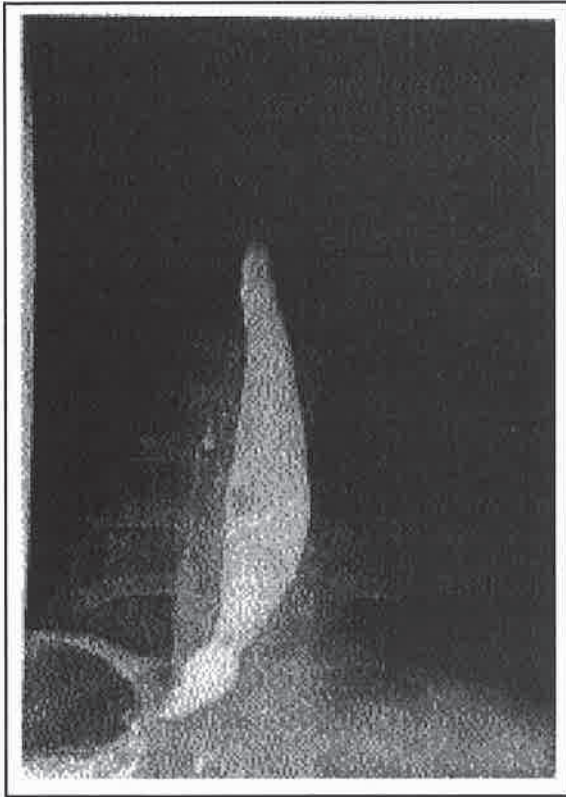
Proximal gastrointestinal system X-rays with barium swallow showed a Schatzki Ring three centimeters above the diaphragm.
